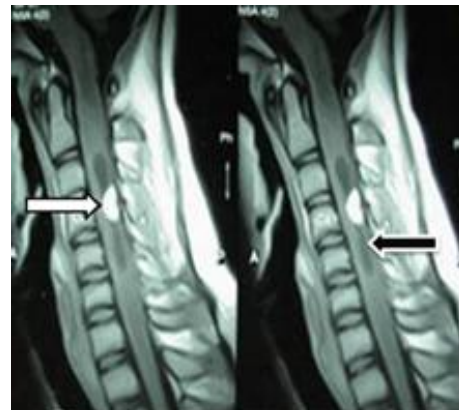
MRI image of intramedullary hemangioblastoma
